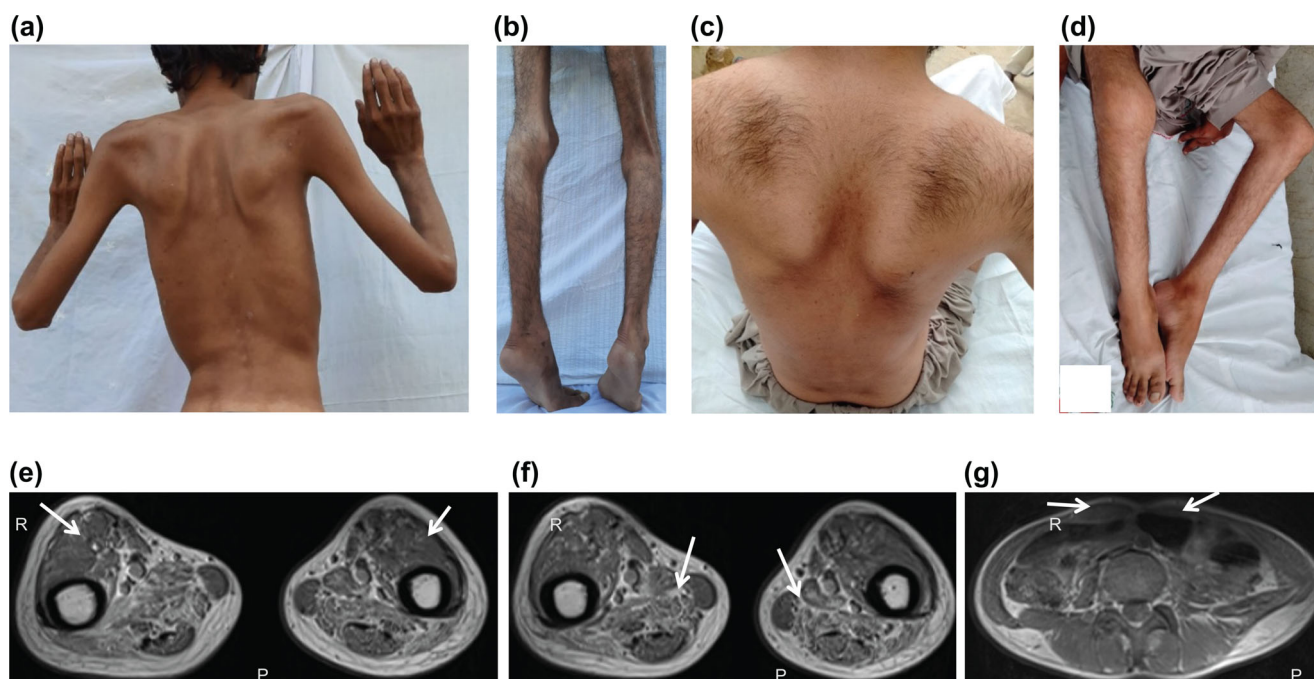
Clinical features of affected individuals homozygous for the CAPN3 c.379 + 3A>G variant. (a, b) Images of upper body (back) with scapular winging (a), and legs (b) of individual II-7 from family 2. (c, d) Images of upper body (back) in a sitting position showing scapular winging (c), and legs (d) of individual II-1 from family 1. (e–g) Thigh MRI images of individual II-7 from family 2. Atrophy of anterior compartment muscles with relative sparing of vastus lateralis are marked by arrows
